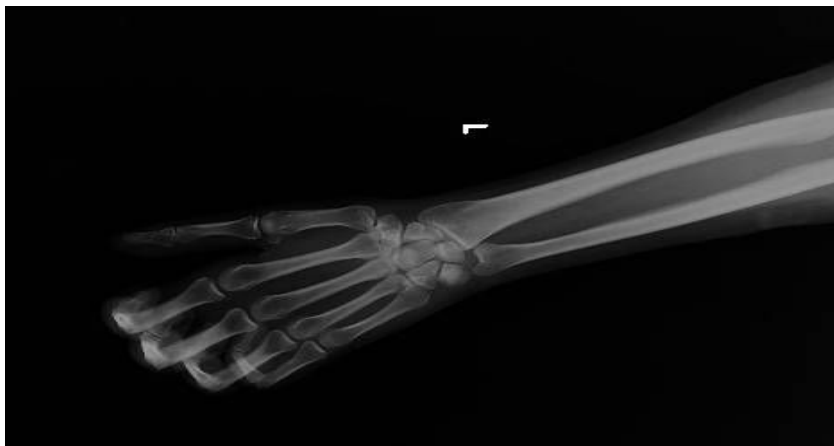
Radiographic measurement of ROM.
